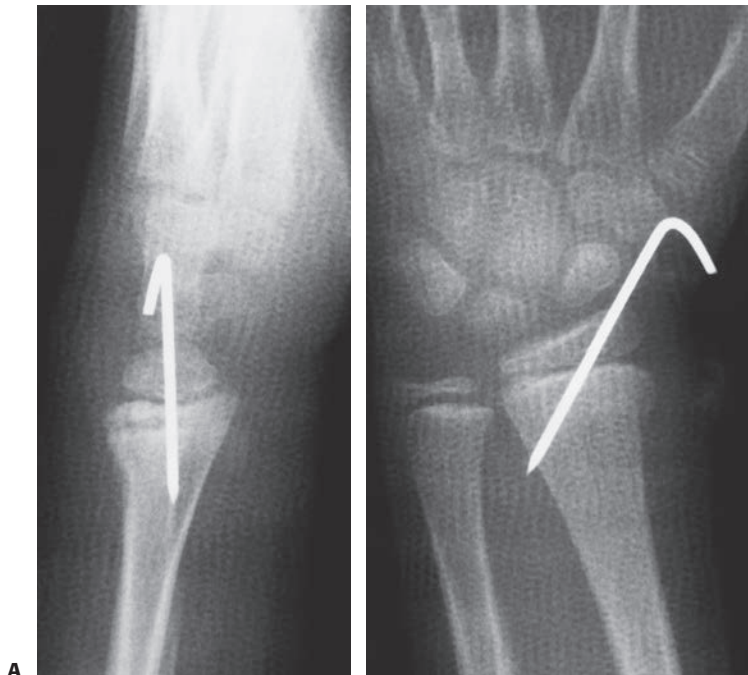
A: AP and lateral radiographs of displaced Salter–Harris type II fracture pinned with a single pin.
